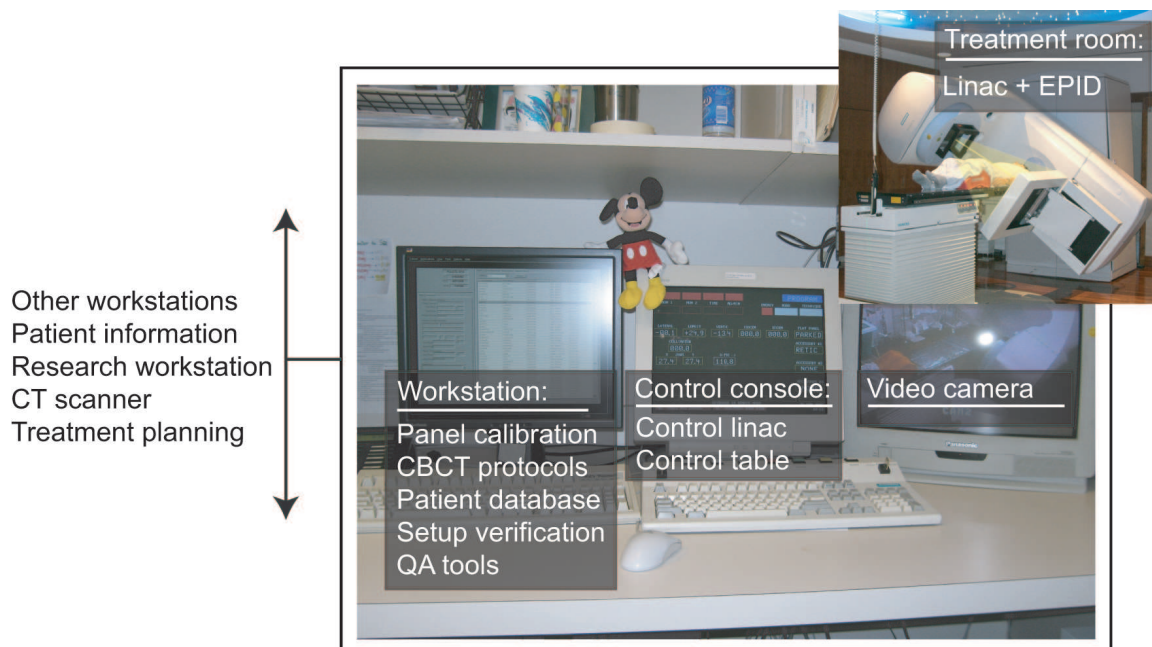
Major system components for MVCBCT imaging. Nearly all the calibrations and clinical tasks related to MVCBCT are performed with the computer workstation. A separate research workstation was used to produce most of the results (offline reconstruction, image processing and analysis) presented in the dissertation.
